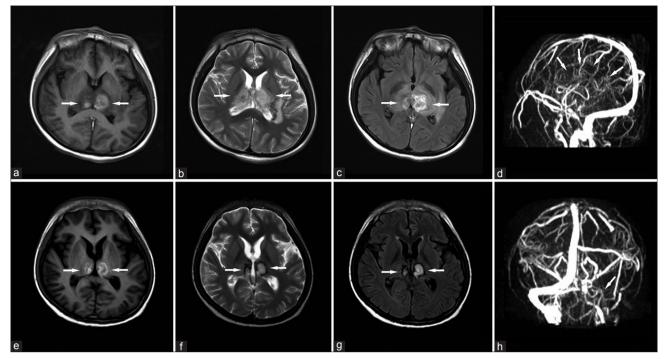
Progressive venous thrombosis in an 18-year-old man with Down syndrome. (a-c) MRI at admission demonstrated the lesions in the bithalamus, bilateral periventricular white matte and intraventricular parts (white arrows); (d and h) MRV revealed thrombosis in inferior sagittal sinus, great cerebral vein, left sigmoid sinus and straight sinus (the white arrow indicates thrombosis areas); (e-g) MRI at follow-up showed that the bithalamus and left periventricular parts had abnormal signals, and the lesions were significantly improved (white arrows). (a and e) Contrast-enhanced T1-weighted image. (b and f) Contrast-enhanced T2-weighted image. (c and g) T2/FLAIR image. (d) MRV at sagittal section. (h) MRV at coronal section. MRI: Magnetic resonance imaging; MRV: Magnetic resonance venography; FLAIR: Fluid attenuation inversion recover.
